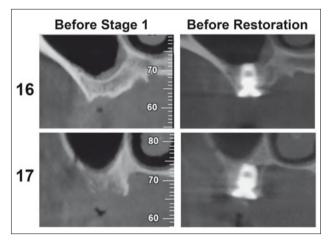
Changes of the sinus height as depicted by CBCT.
